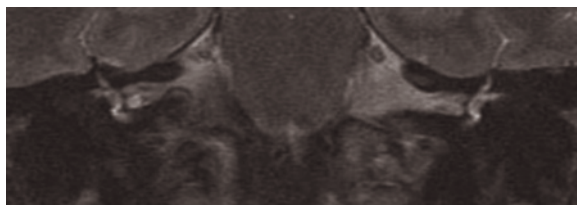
Coronal T2-weighted MR image. Stenosis of the right internal auditory canal.
